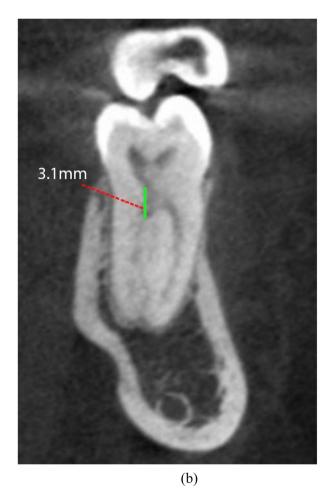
CBCT of mandibular first molar. (a) Axial view measuring the distance between the orifice of MD canal and main distal canals.(b) Sagittal view measuring the distance from CEJ to the MD canal orifice. CBCT: Cone-beam computed tomography, MD: Middle distal, CEJ: Cementoenamel junction.
